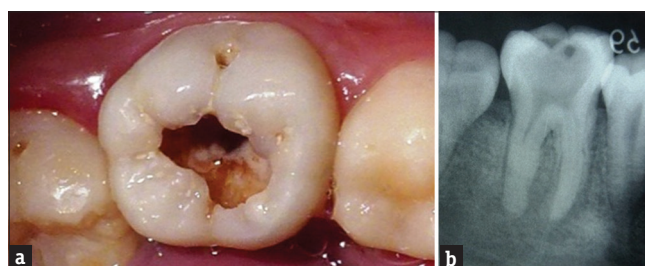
(a) Occlusal view of the mandibular left first molar. (b) Radiograph shows profound caries extending to the pulp space with no periapical radiolucency
